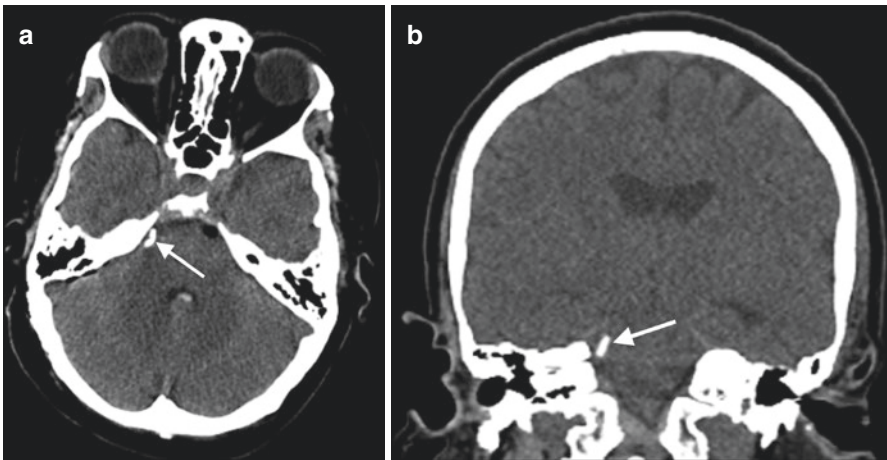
Axial (a) and coronal reformatted (b) CT images show the expected hyperdense cylindrical appearance of a surgical pledget along the lateral aspect of the right CN V root entry zone. Pledgets may be straight or curved, as in this case
